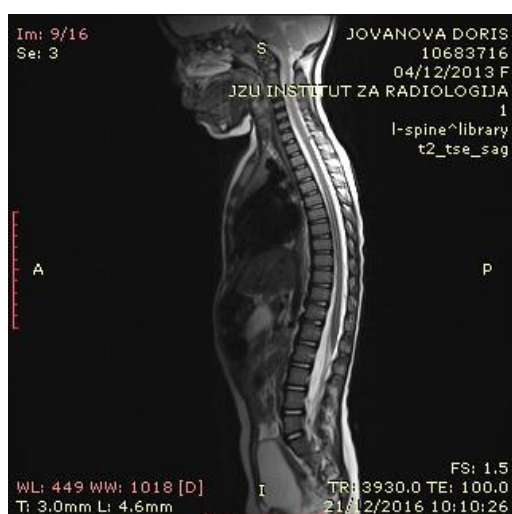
MRI of the patient which shows tethering of the cord
